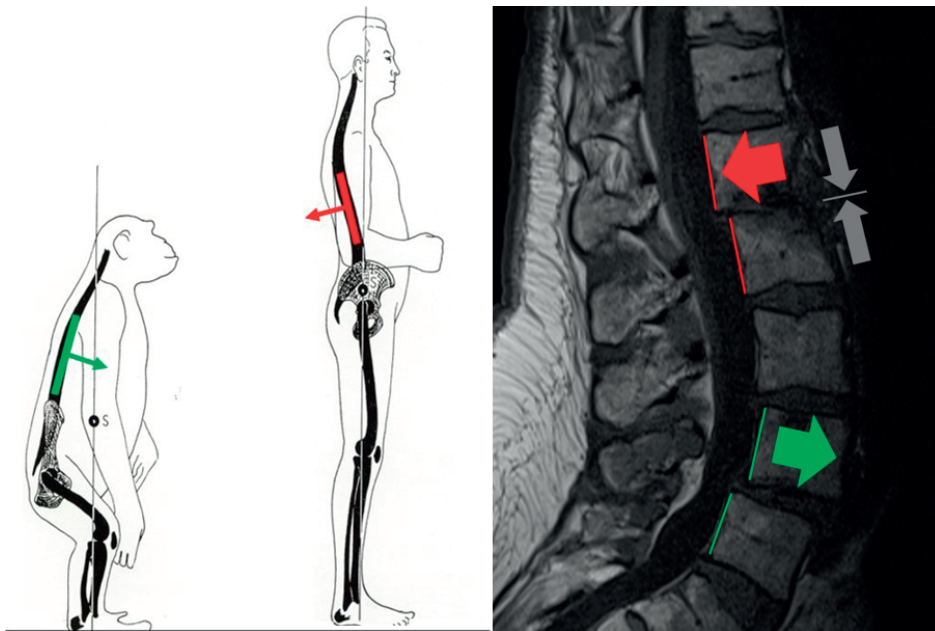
All spines consist of anterior inclined vertebrae (in green). The unique standing position and sagittal spinal morphology of man results in posterior inclined vertebrae as well (in red). Because of the unique position, three forces act on the human spine. These three forces (anterior shear force, posterior shear force and axial force), including the *unique posterior shear*, acting on the human spine can easily be appreciated in this MRI of a spine that demonstrates them all, axial (grey), anterior (green) and posterior (red) force.
